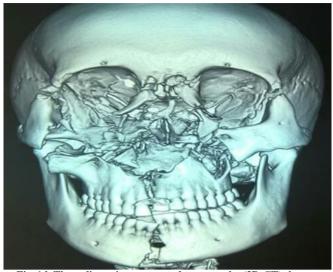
Three dimensions computed tomography (3D-CT) shows mandibular symphyseal fracture in a pan facial trauma patient.
